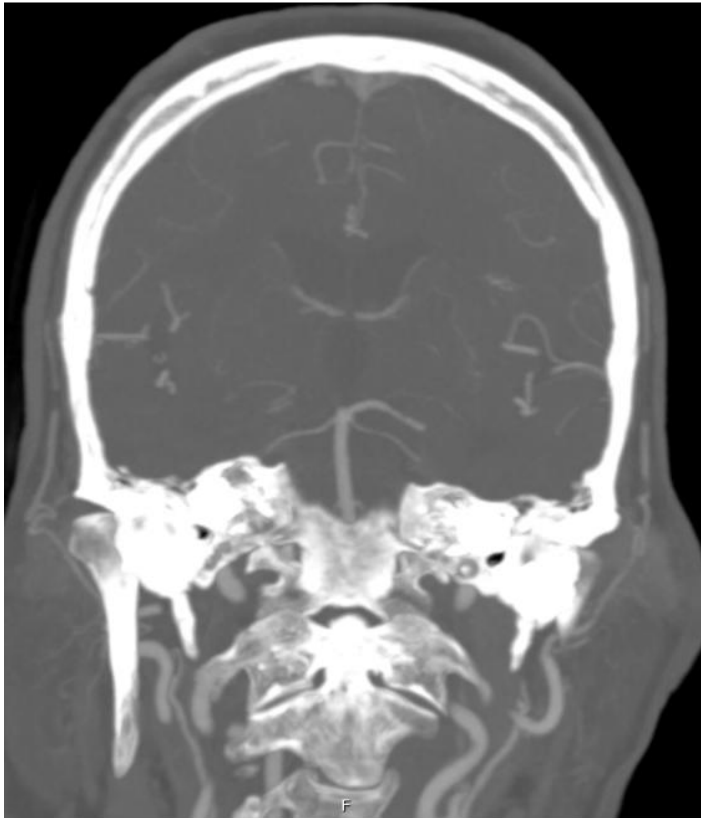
Coronal maximum intensity projection (MIP) from computed tomography angiography (CTA) showing absence of opacification of the right posterior cerebral artery at its proximal segment, consistent with occlusion involving the origin of the artery of Percheron.
